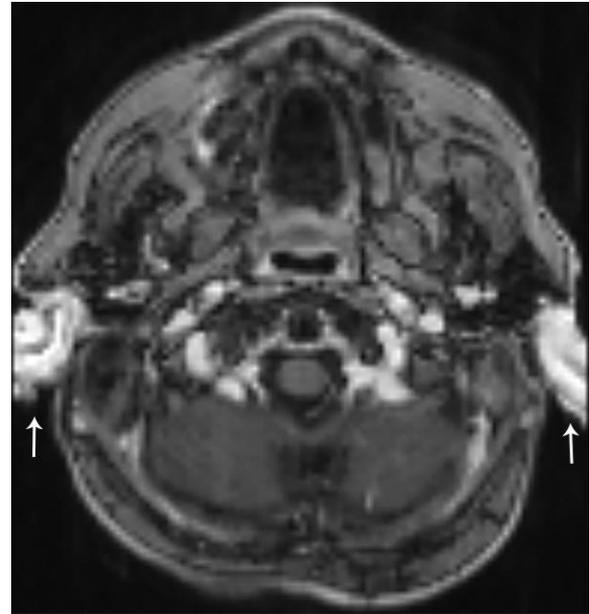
Brain MRI, axial post-contrast T1-weighted image. Bilateral auricles are gadolinium-enhancing (arrows).
